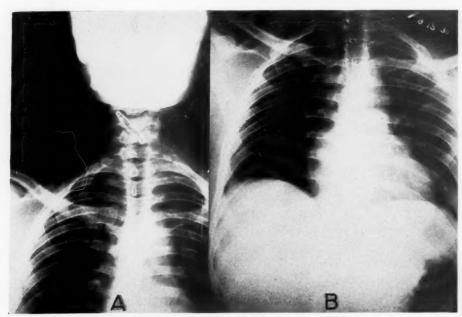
Roentgenograms of the patient with extensive gangrene of the left forearm. A. Bilateral cervical ribs—right complete, left incomplete and attached to the first rib. B. The distal portion of the left cervical rib has been removed—relieving pressure on the subclavian artery and brachial plexus.
